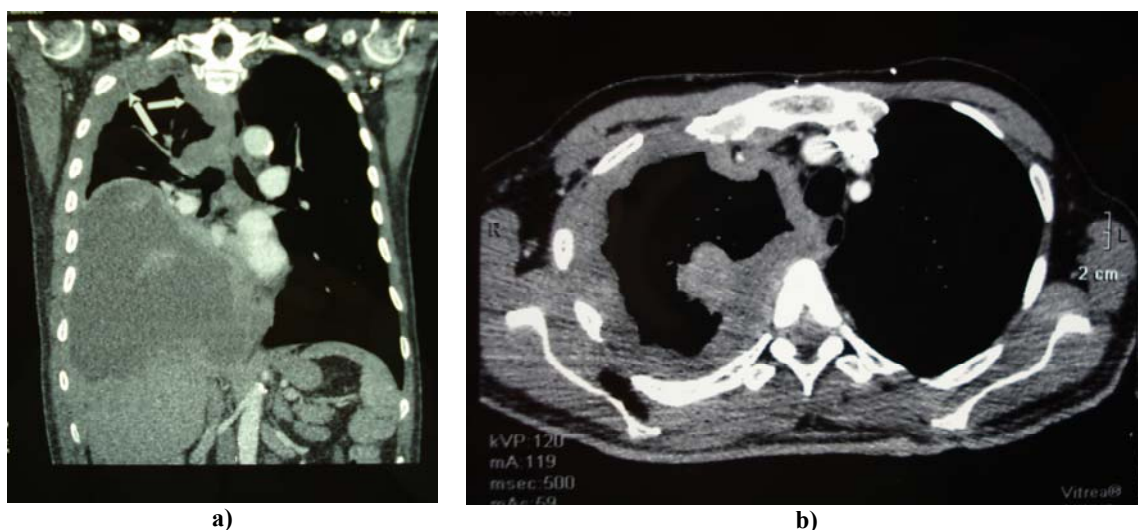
a) Axial and b) Coronal section of computed tomography scan showing the thickened pleura apically and to the posterior along the upper right lobe in addition to the existence of massive pleural effusion. In the upper right lobe there is a subpleural condensation about 30 mm in diameter. Precarinal lymph nodes with 15 mm of size.
